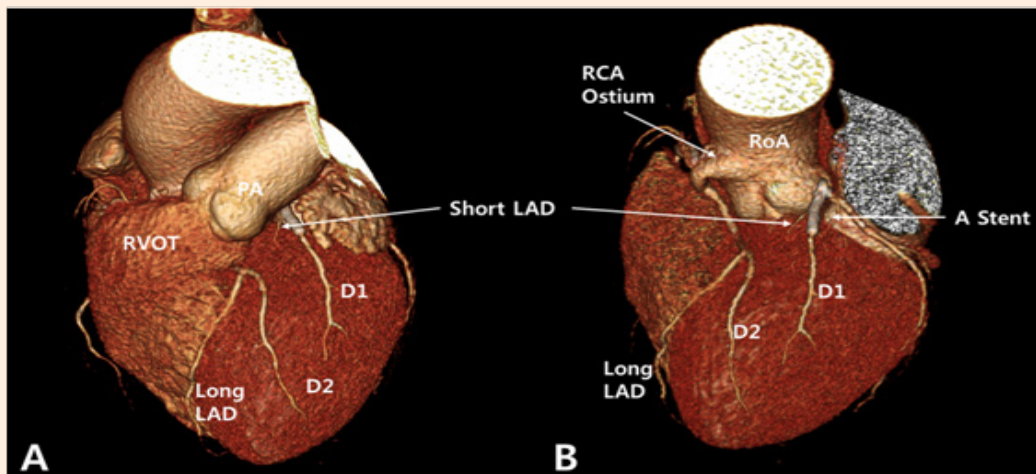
Computed tomographic coronary angiography.
